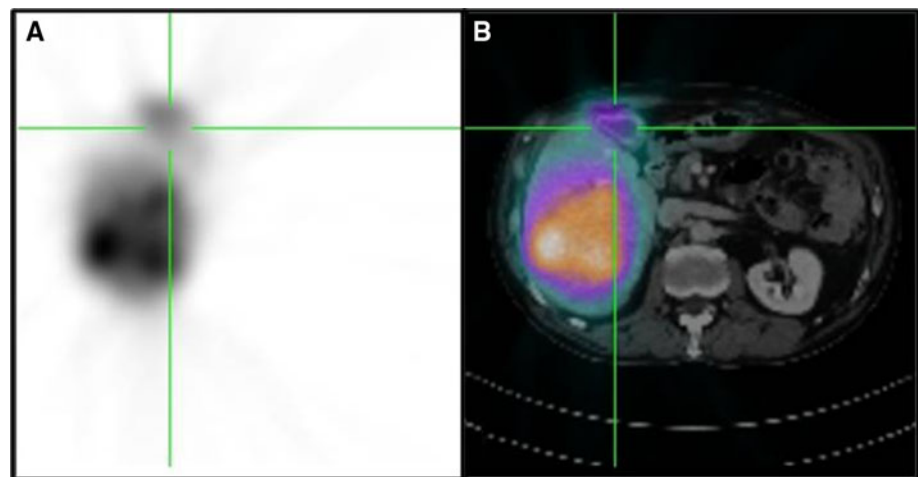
SPECT/CT image of the abdomen (a SPECT *axial view*, b *axial fused image*) showing the presence of extrahepatic accumulation in the gallbladder after ^{99m}Tc -MAA injection (color figure online)
